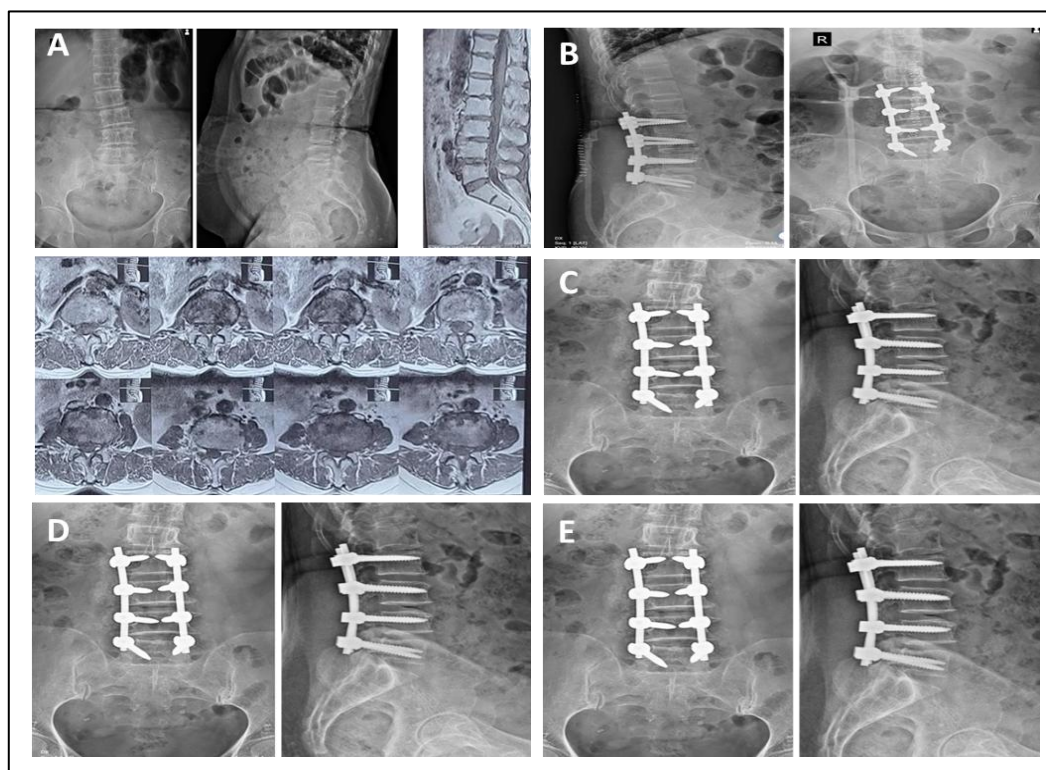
Case 2 showing pre-OP X-ray and MRI and post-OP X-rays; A) pre-op X-ray and MRI (L2-L5 LCS), B) immediate post-op X-ray (L2-L5 PLF), C) 3- months post-op X-ray, D) 6- months post-op X-ray, E) 1-year post-op X-ray.
